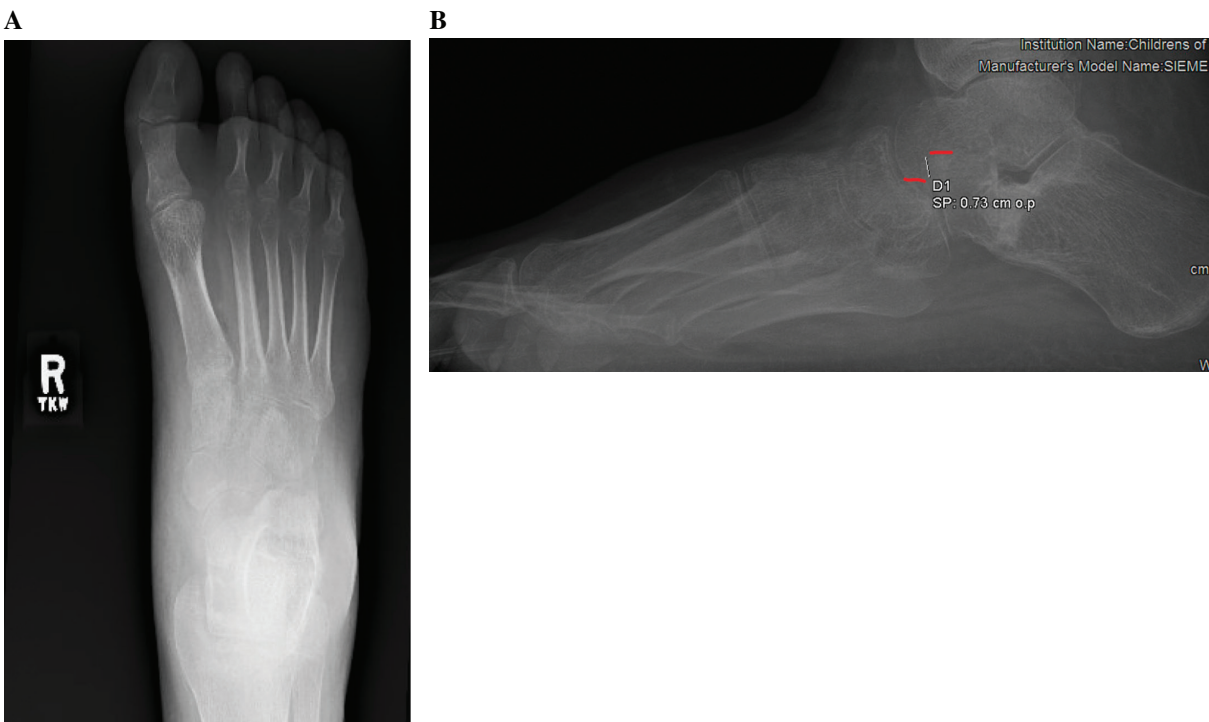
(A) AP and (B) lateral 12-week postoperative radiographs demonstrating persistent CC joint subluxation following pin removal.
